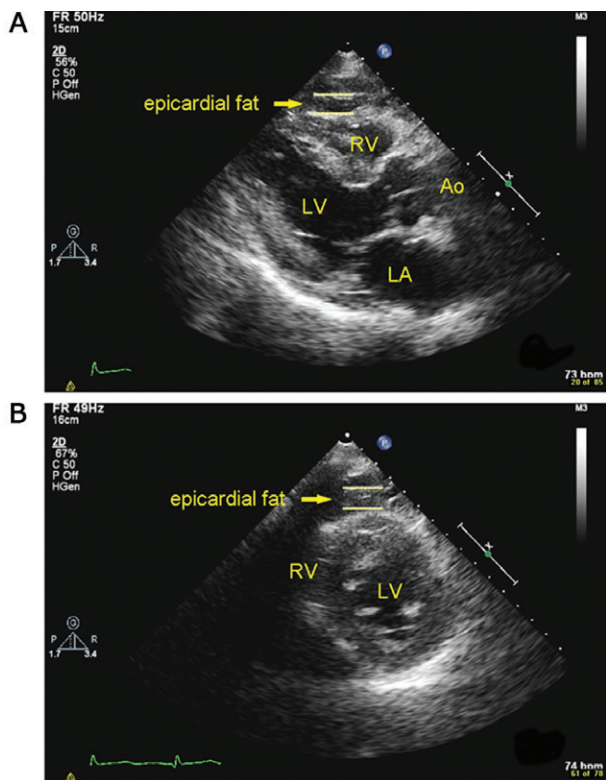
Epicardial fat thickness in echocardiography. EFT was defined as the relatively echo-free space between the outer wall of the myocardium and the visceral layer of the pericardium. Abbreviations: Ao, aorta; LA, left atrium; LV, left ventricle; RV, right ventricle.
